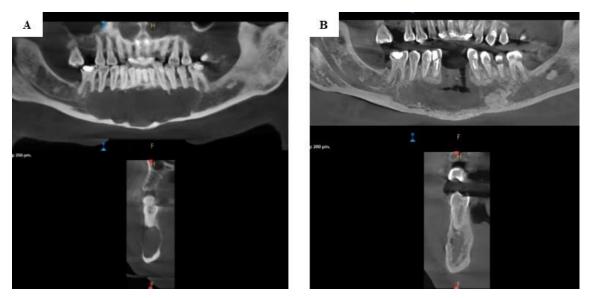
CBCT images before (A) and after (B) the cystostomy procedure. The author's own work.
